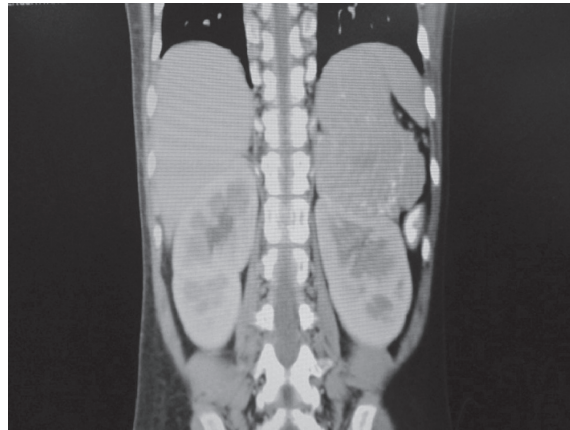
A coronal view from the contrast-enhanced CT scan on the portovenous phase, shows this huge mass at the posterior left upper quadrant, pressing the upper pole of left kidney.
